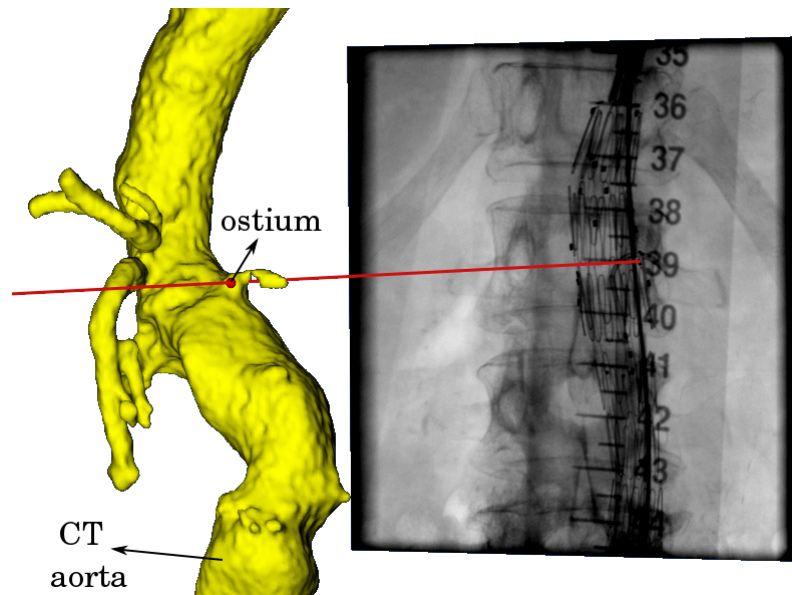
Example of CT to fluoroscopy registration. After registration, the position of the renal ostium on the surface of the CT aorta is projected into the fluoroscopy image to provide information about the current position of the ostium relative to instruments.
